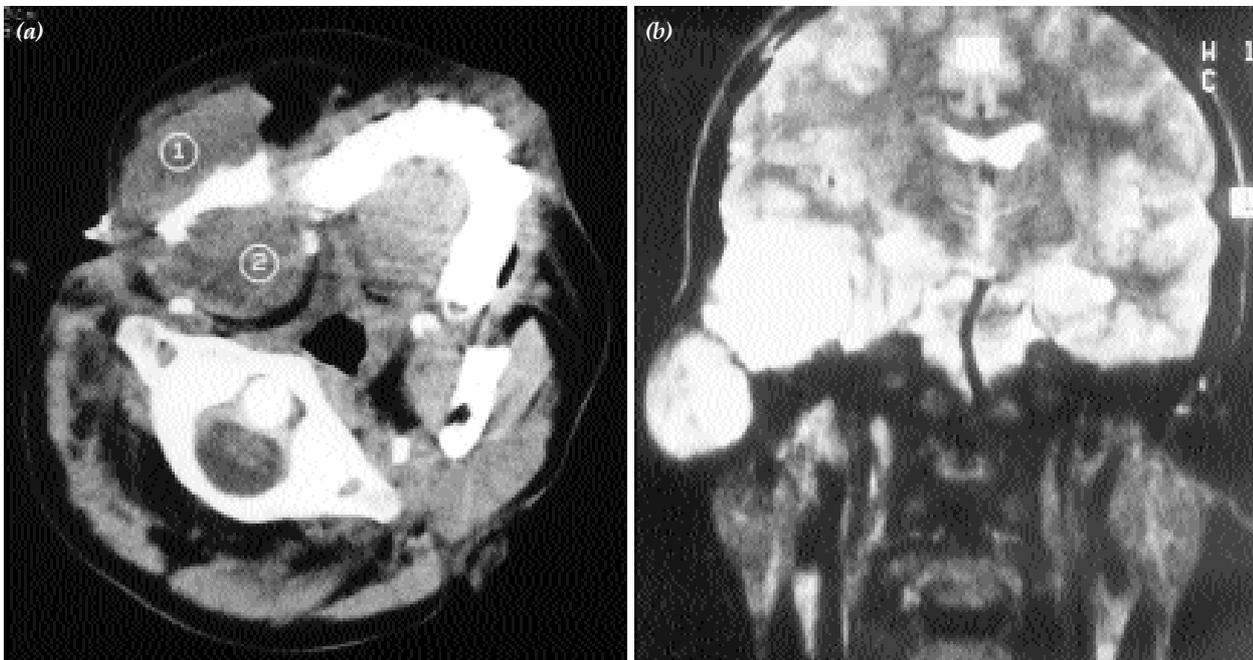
(a) Axial computed tomography showing a destructive lesion extensively involving the right parotid and the mandible. (b) T₂-weighted coronal magnetic resonance image showing a hyperintense mass involving the skull base, with invasion to the intracranial space.
